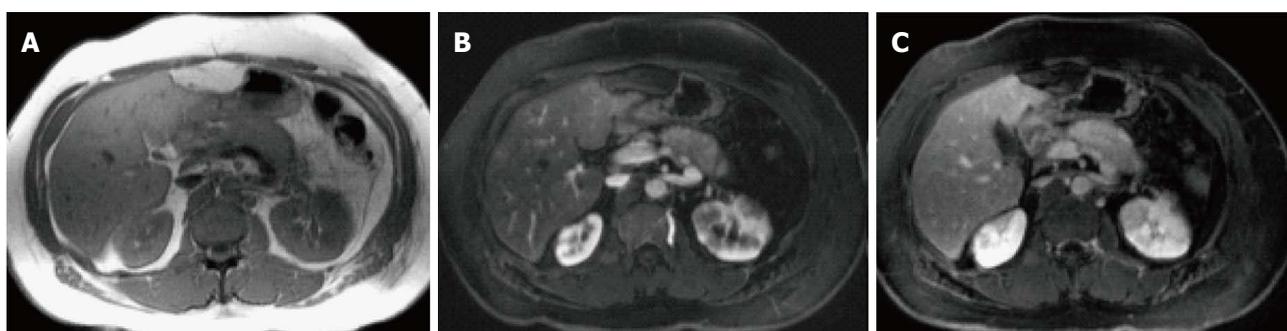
Autoimmune pancreatitis. A: GRE T1-weighted image; B, C: Post-contrast 3D-GRE T1-weighted images with fat-suppression during the late arterial and portal venous phases. There is evidence of diffuse pancreatic swelling with reduced T1 signal, loss of the normal pancreatic lobulation and obliteration of the pancreatic duct, associated with a rim of low T1 signal (A). The pancreas demonstrates diffuse reduced enhancement on the late arterial phase and progression of enhancement on the portal venous phase in keeping with autoimmune pancreatitis. The patient had significant biliary tree irregularities in keeping with primary sclerosing cholangitis (not shown). Additionally, there are a few bilateral wedge-shaped areas of renal hypo-enhancement in keeping with segmental infarcts.
